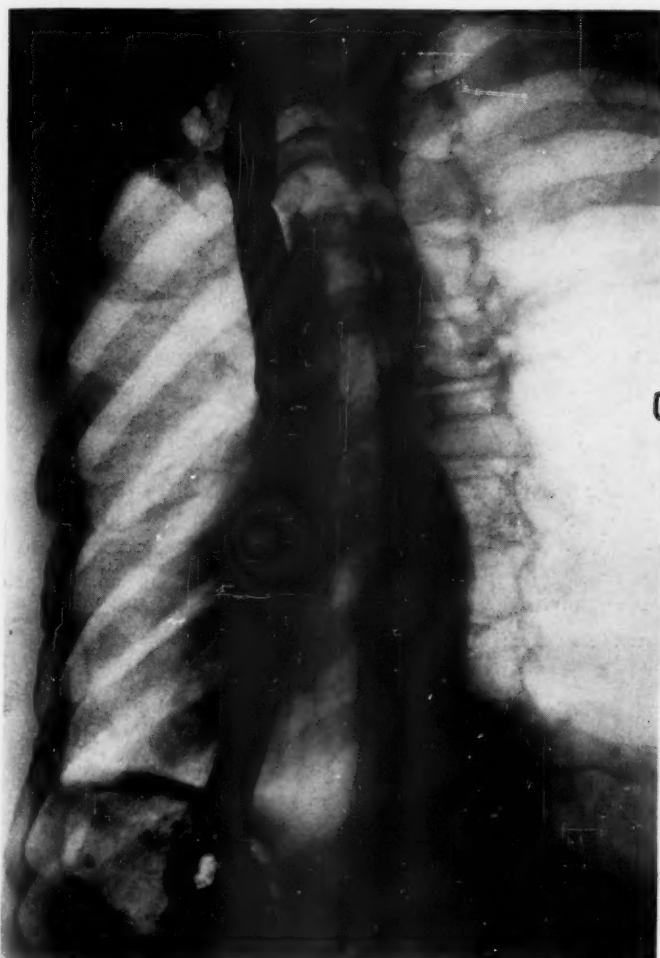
Roentgenogram demonstrating the function of new "skin tube" esophagus. Food passes down very rapidly by gravity plus muscular contraction of pharynx and esophagus stump.
